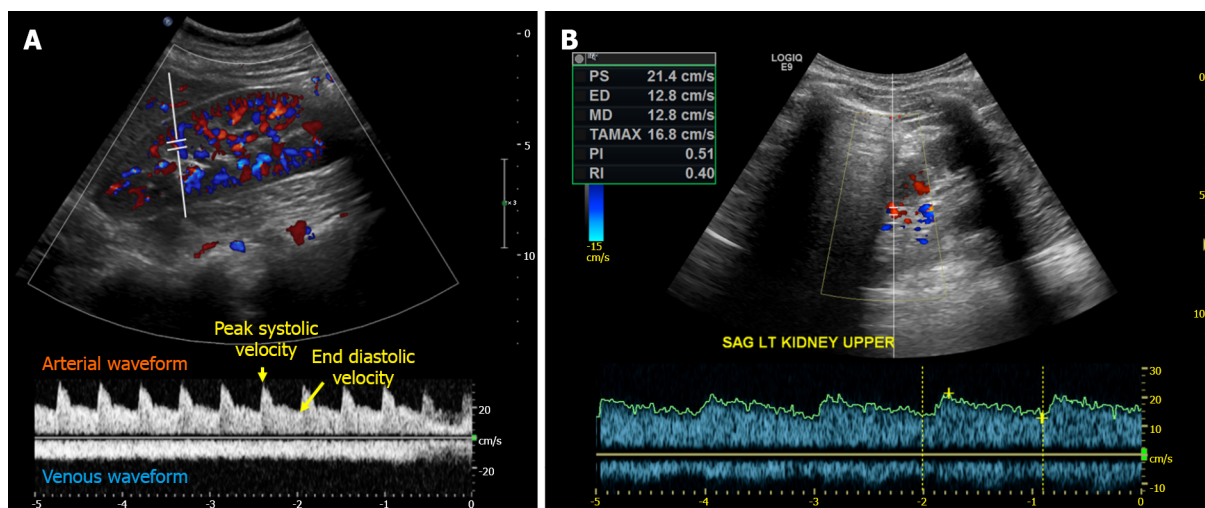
Doppler components of extended VexUS examination. Figure adapted from NephroPOCUS.com with permission (corresponding author's educational website)-<https://nephropocus.com/2022/11/28/hemodynamic-pocus-in-cirrhosis-think-beyond-the-ivc/>.
